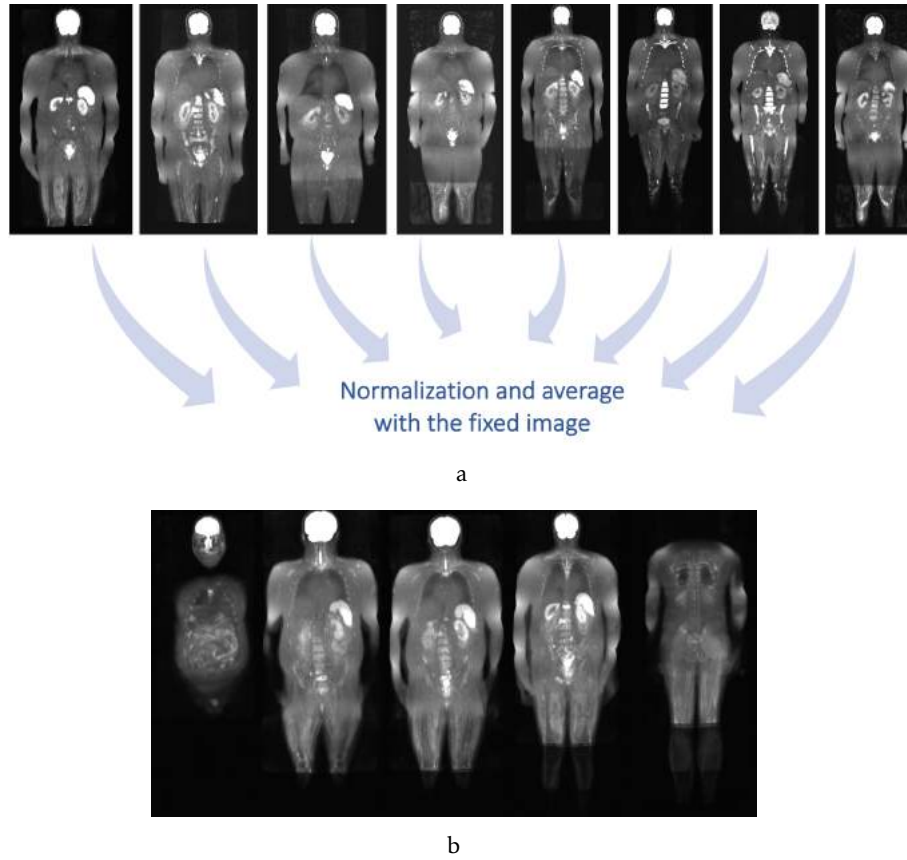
First mean male image, built with nine DWI male images. a) The top eight images are the result of the rigid, affine and B-spline transformations, applied to the eight moving images of figure 5.2 section 5.3.1.1. Then, these eight images and the fixed image were normalized and averaged. b) The bottom image shows five representative coronal slices of the mean male image. Although the brain shows very good alignment, the kidneys, spleen and vertebrae still need improvement.
